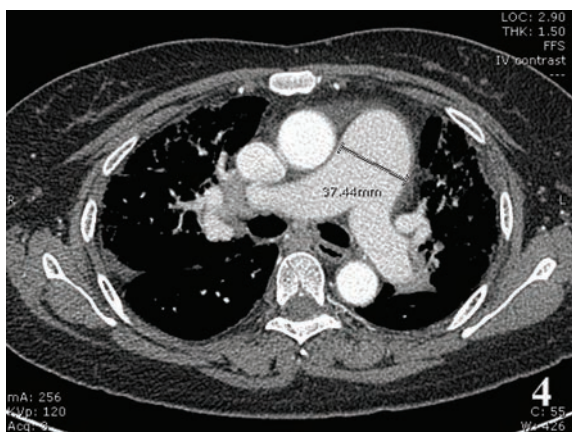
The axial CT scan of the chest (mediastinal window) shows enlargement of pulmonary trunk, measured about 3.7 cm, which indicates pulmonary hypertension.
